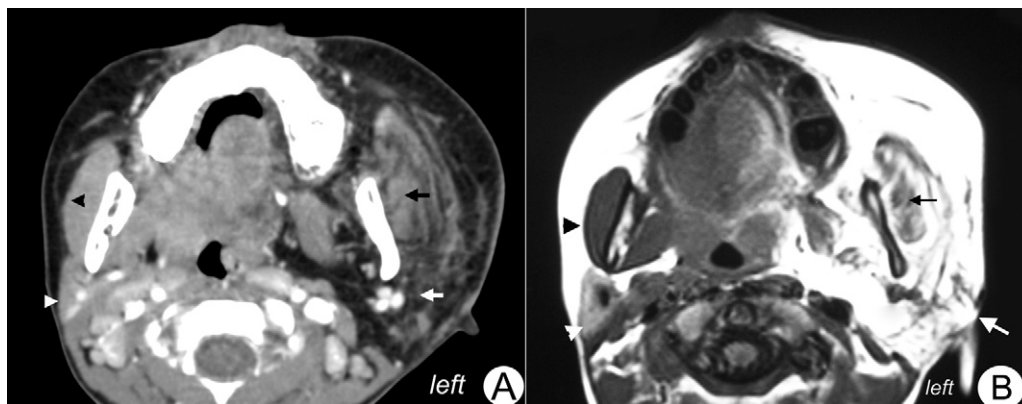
Axial computed tomography (CT; A) and magnetic resonance imaging (MRI; B) show abundant fat tissue infiltrating the left masseter (black arrow), parotid gland (white arrow), pterygomandibular, and parapharyngeal spaces. Also note the normal appearance of the masseter (black arrowhead) and parotid gland (white arrowhead) on the right side. The fat tissue could be determined by its specific CT attenuation ( $-100$  and  $-80$  Hu before and after enhancement (A)). Fat tissue infiltration observed on MRI shows high signal intensity on the T1-weighted image (B).
